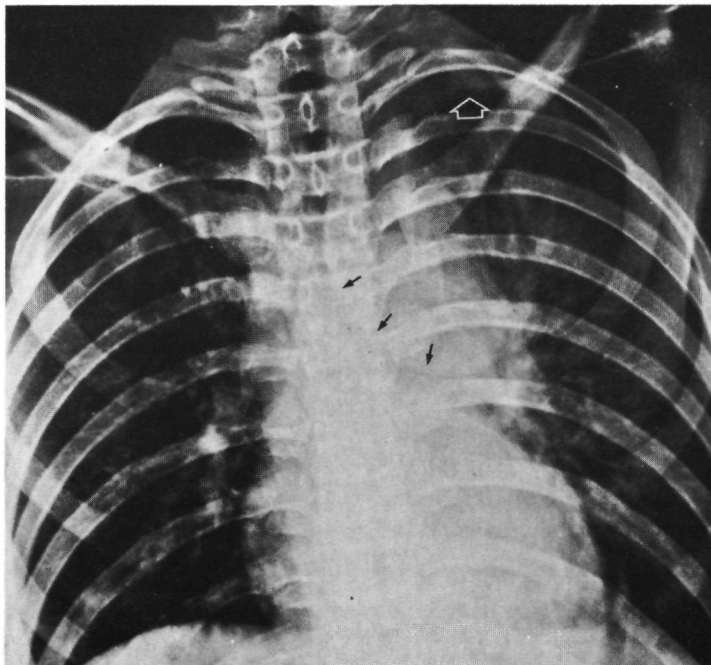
4 Female, 18 years, bicyclist, TAR. Uneventful recovery after operation. Chest X-ray: widening and unsharp contour of the mediastinal shadow (8.5 cm), opacified pulmonary window with discrete displacement of left main bronchus (arrows). Apical cap (open arrow).
